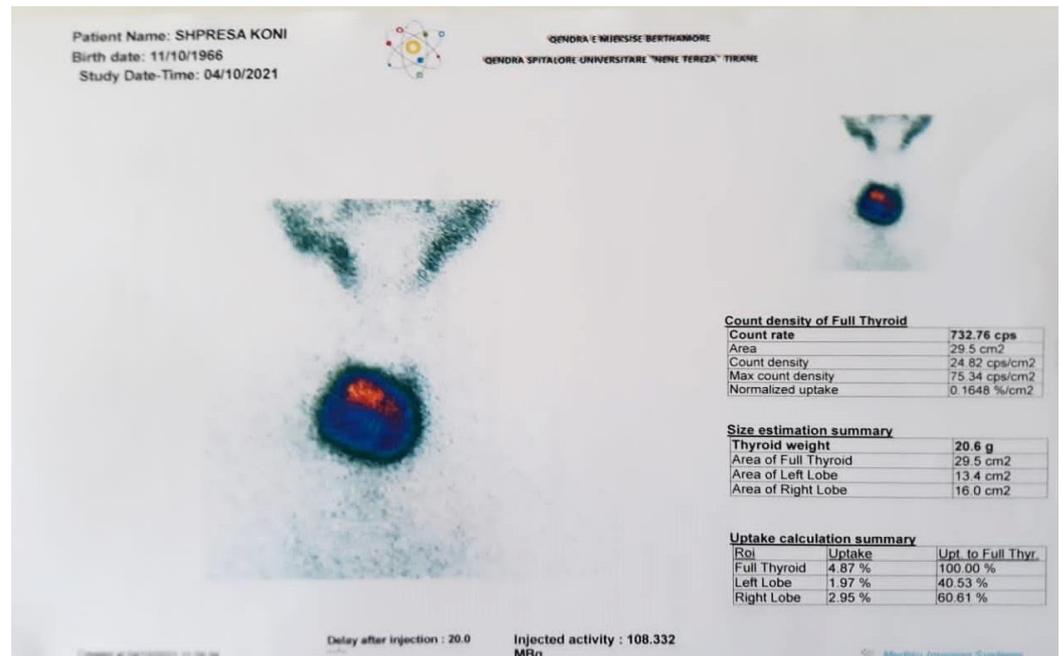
Thyroid scintigraphy scan with ^{99m}Tc
